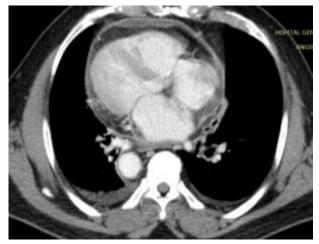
Chest CT in axial section, mediastinal window, with PDC injection, showing the apex of the heart on the right and the descending aorta on the right. NB: there is pericarditis.
